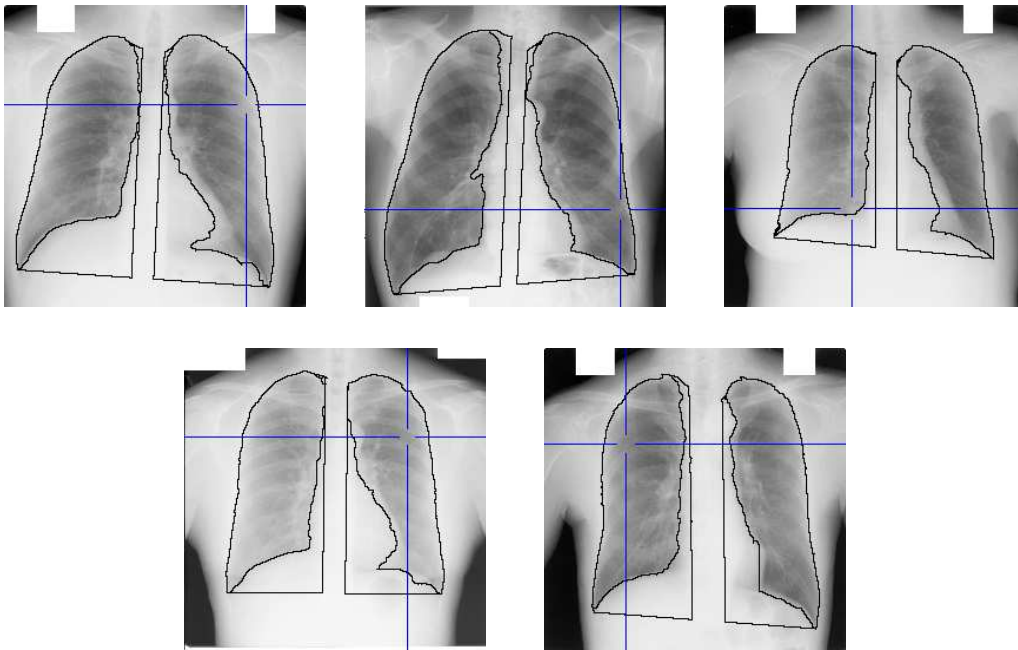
Radiographs containing nodules lost
